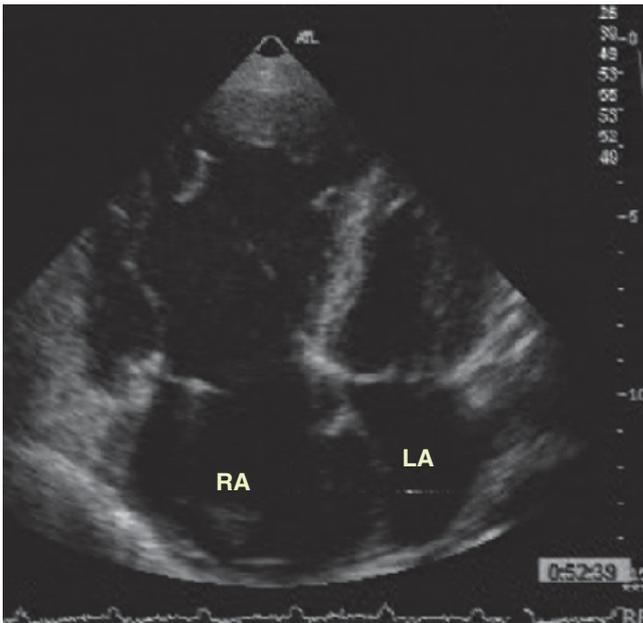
Apical four-chamber view from the same patient as in Fig. 25.6 demonstrating the markedly dilated RV. This patient can be compared with patient in Fig. 25.4 where the aneurysm was very discrete
